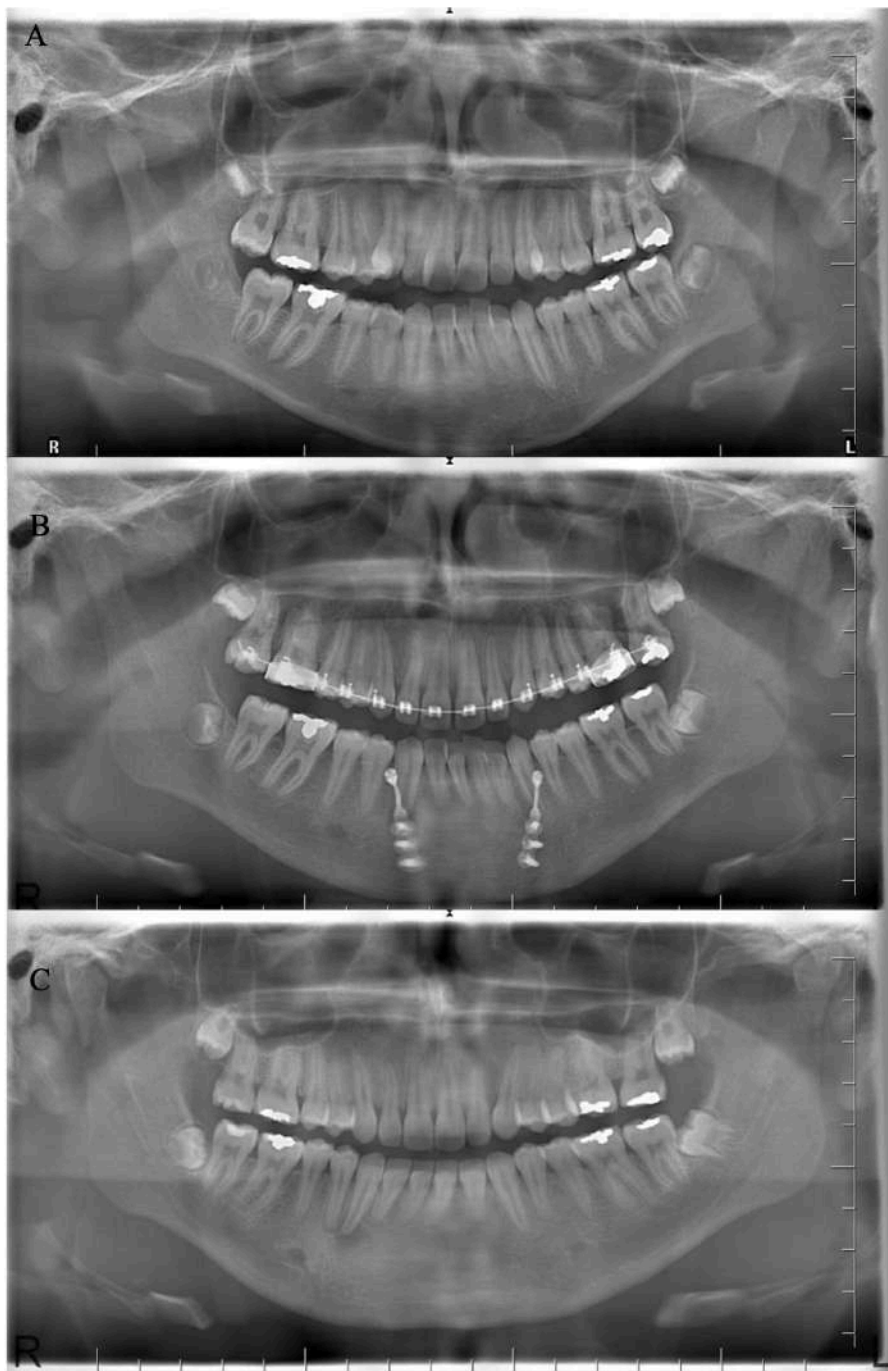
Panoramic Radiographs A. Initial (02/2016) B. During orthodontic treatment (06/2018) C. After orthodontic treatment (12/2020)
